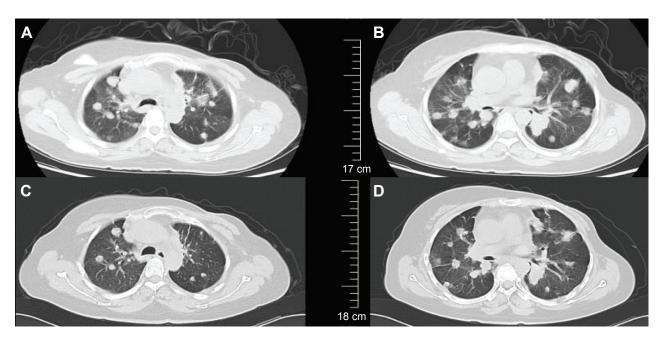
Chest computed tomography images showing the response to everolimus combined with fulvestrant.
